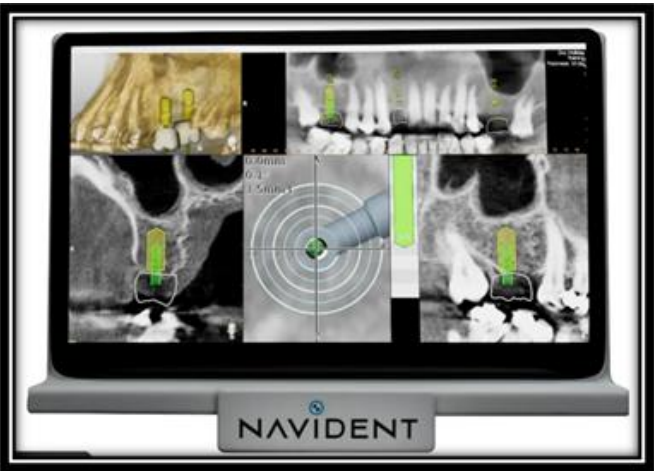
CBCT softwares for DNS (a) Navident
